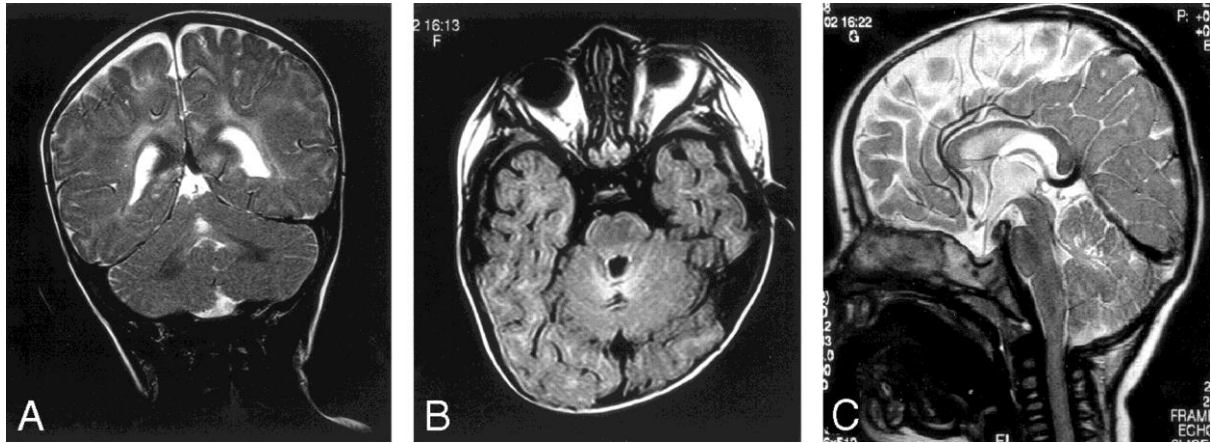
Images of ALV signal change and volume loss a) coronal T2, b) axial FLAIR, c) sagittal T2
